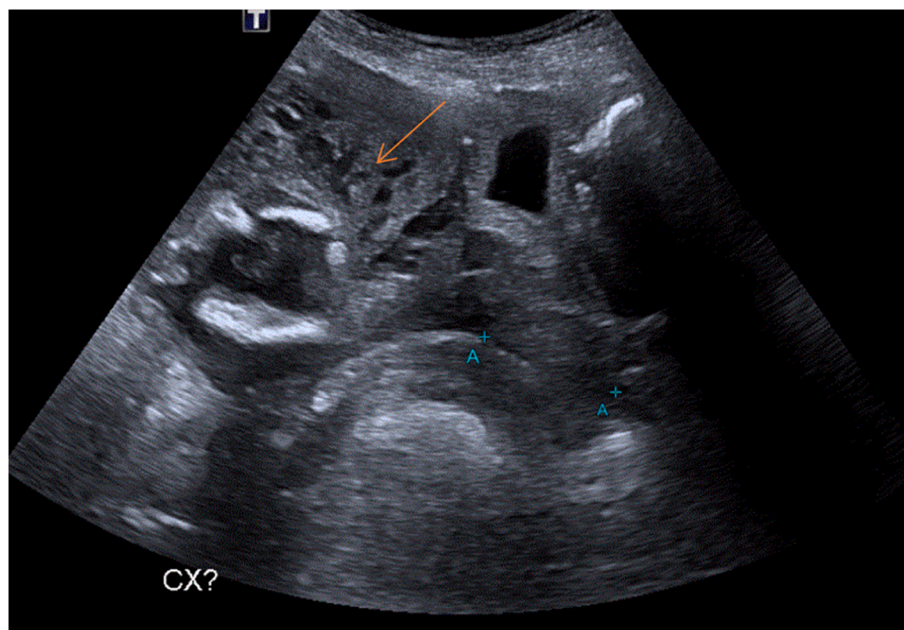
Ultrasound evidence of finger-like placental projections (arrow) invading beyond decidua basalis, suspicious of placenta accreta spectrum.
